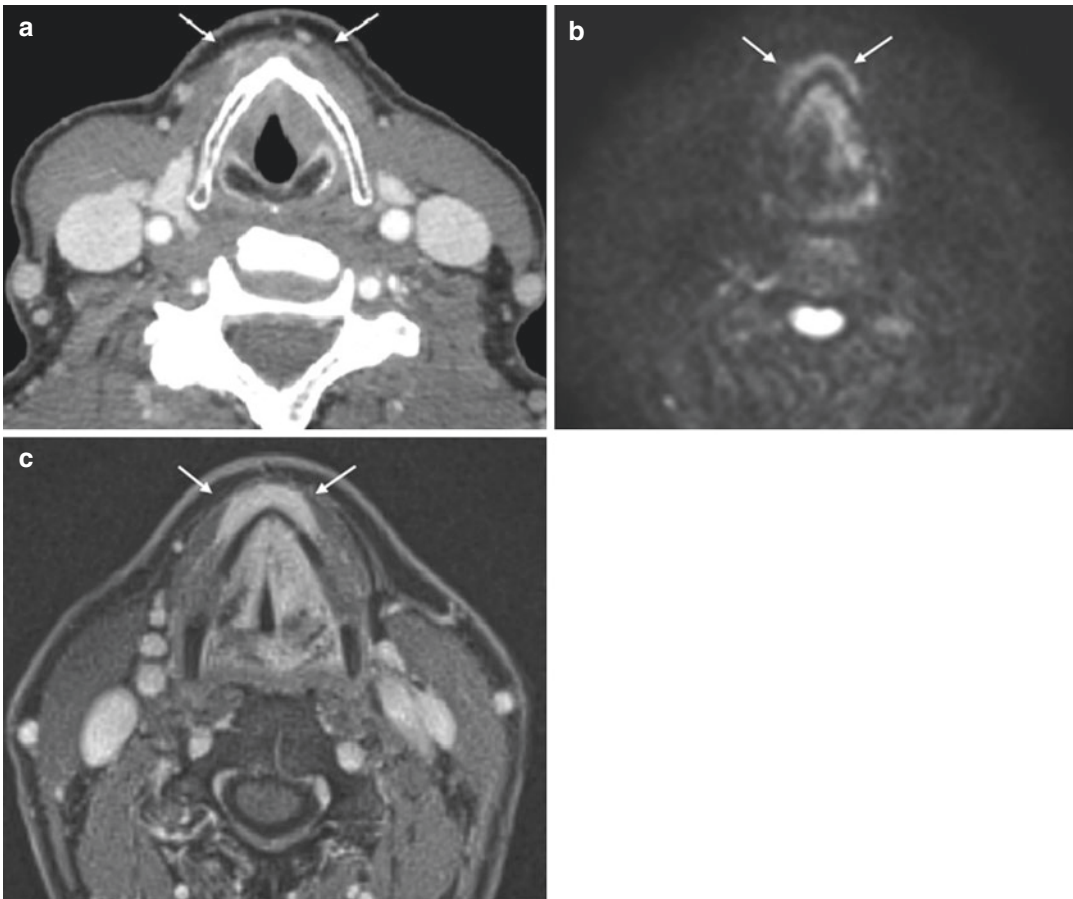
Laryngeal cancer T4: invasion of tissue beyond the larynx with involvement of strap muscles (white arrows). (a) CT scan. (b) High-resolution DWI. (c) 3D T1w post-contrast
